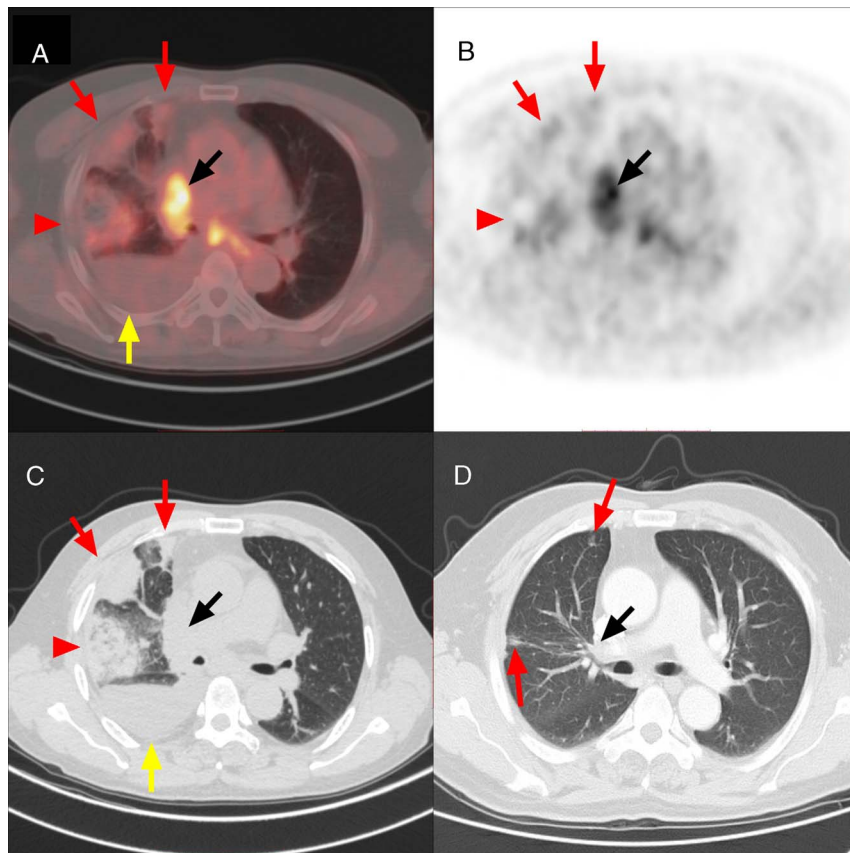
A 66-year-old man with small cell lung cancer of the right hilum. Axial PET/CT (A), PET (B), and chest lung window (C) showed an FDG hypermetabolic mass ($SUV_{max} = 8.4$) in the right hilum (black arrow). Images showed multiple subpleural pulmonary infarcts (red arrow) with homogeneous or bubbly consolidation, which exhibited mild heterogeneous hypermetabolism ($SUV_{max} = 3.2, 2.5,$ and 2.1). The metabolic patterns were “rim sign” (short arrow) or “mismatch between PET and CT” (long arrow). Note the right pleural effusion (yellow arrow). After 2 months of antitumor treatment, axial thin-slice chest CT (D) showed the mass in the right hilum was significantly reduced, and the right pulmonary artery was patent (black arrow). Residual fibrous scars were noted in the upper lobe of the right lung (red arrow).
